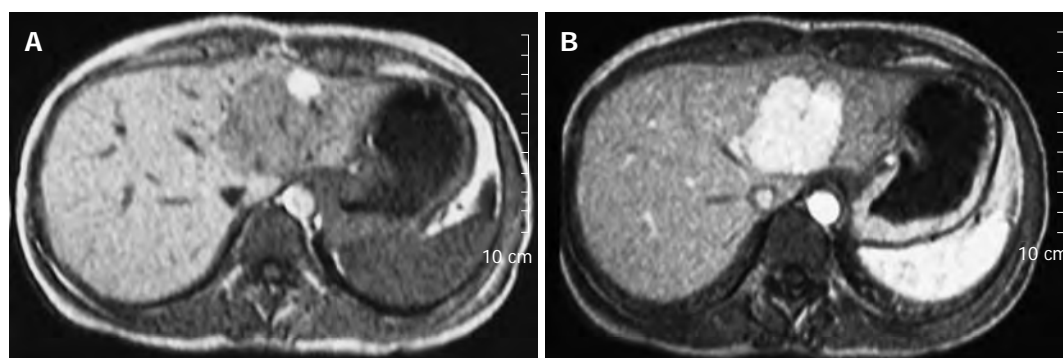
Magnetic resonance imaging showing the liver lesion in segments III/IV. Note the mass effect on the middle and left hepatic veins.
